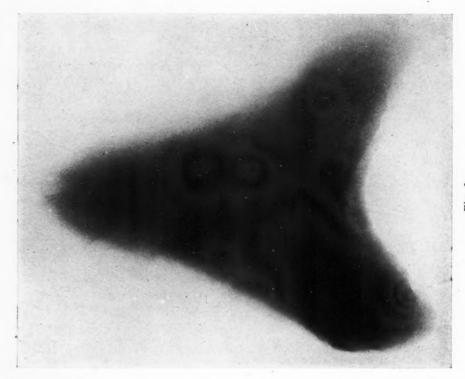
Radiographs of teeth of shark.
